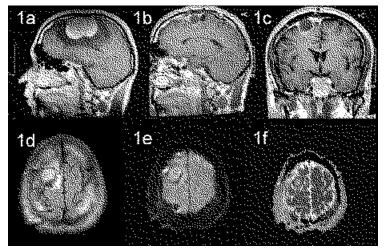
(a) Preoperative sagittal contrast enhanced T1 weighted images showing homogeneously enhanced right parasagittal frontal meningioma with surrounding hypointense edema. Contrast enhanced sagittal (b) and coronal (c) T1 weighted images showing peripheral intense enhancement of the lesion. (d) Postoperative axial FLAIR (TR/TE/TI; 7800/115/2500 ms) image revealed slightly hyperintense mass lesion with hypointense capsule. (e) DWI (TR/TE; 3400/94 ms, B value of 1000) demonstrated hyperintense content of the mass. (f) ADC map of DWI showing that fluid content was of non-infected type with hypointense fibrous capsule.
